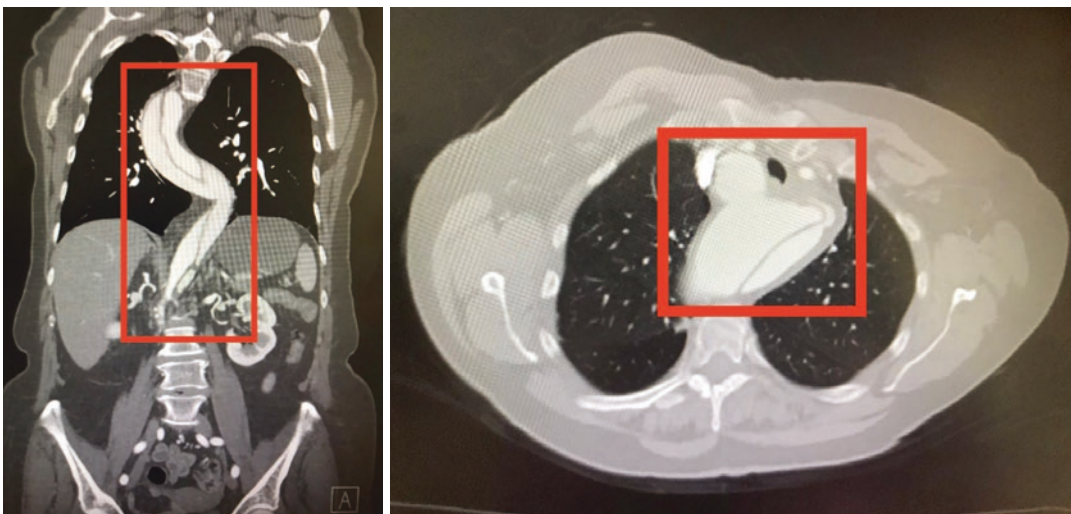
CTA with acute thoracic aortic dissection
